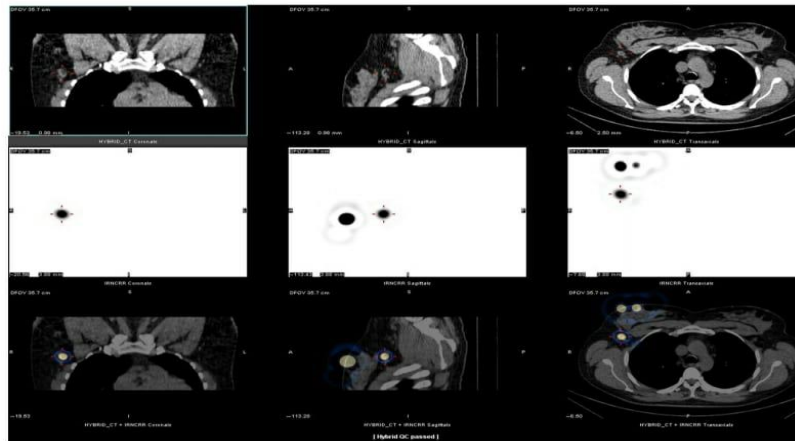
Fused SPECT/CT images provide surgeons with a more accurate anatomical visualisation of the sentinel node with regard to the breast and axilla by depicting the precise location in the axillary area adjacent to the first and second rib saving valuable intraoperative time and increasing surgical confidence. SPECT, single-photon emission computed tomography. Image courtesy of Regional Imaging, a member of I-MED Network Radiology, Wagga Wagga, NSW
